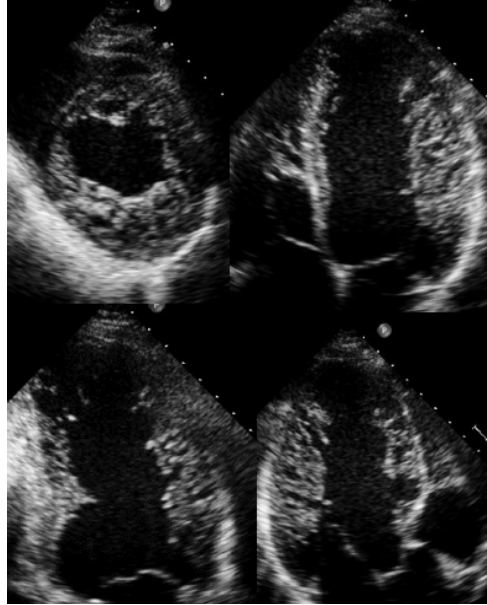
Typical phenotype of noncompaction cardiomyopathy in short-axis view (top left), apical four-chamber view (top right), apical two-chamber view (bottom left) and apical long-axis views (bottom right). Note the presence of trabeculations in posterior wall, anterior septum and lateral wall of the left ventricle.
